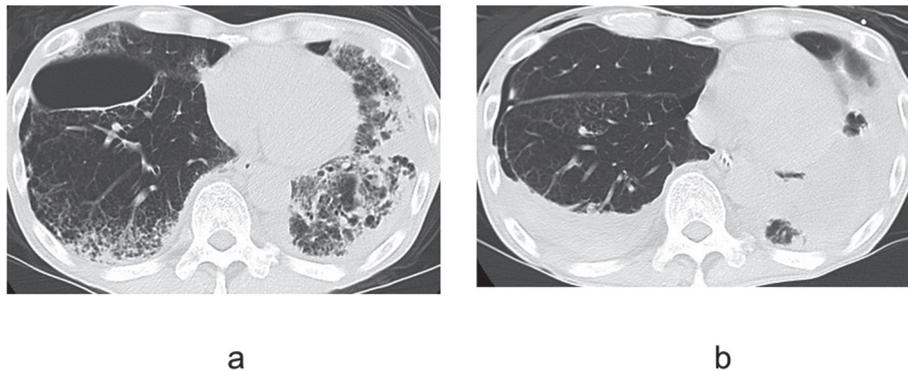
Chest CT on admission showed shadow of interstitial pneumonia (a). Chest CT after conservative therapies (b). The shadow of interstitial pneumonia was improved, and the right lung expanded. This CT revealed blood clots that were used for pleurodesis in right thoracic cavity, the atelectasis in left lower lobe.
